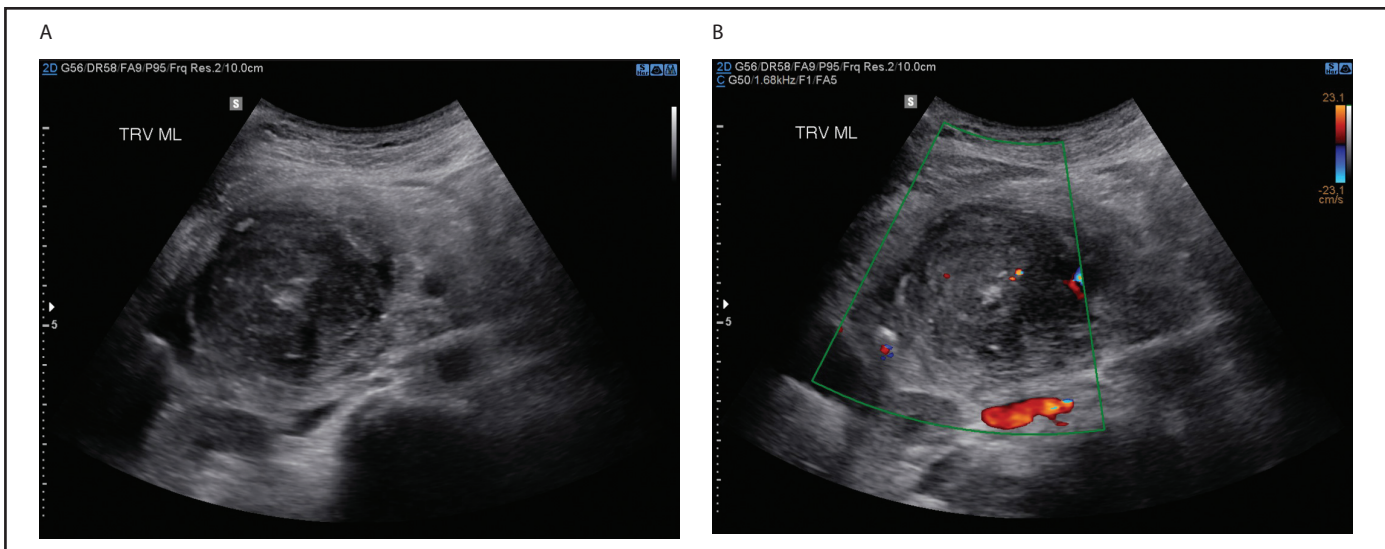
Week 64. (A) Transverse: Pancreatic head lesion- no change from previous. Pancreatic tissue is echogenic. (B) Transverse: Colour Doppler: Pancreatic head lesion with twinkling artifact with peripheral vascularity (same as previous).
